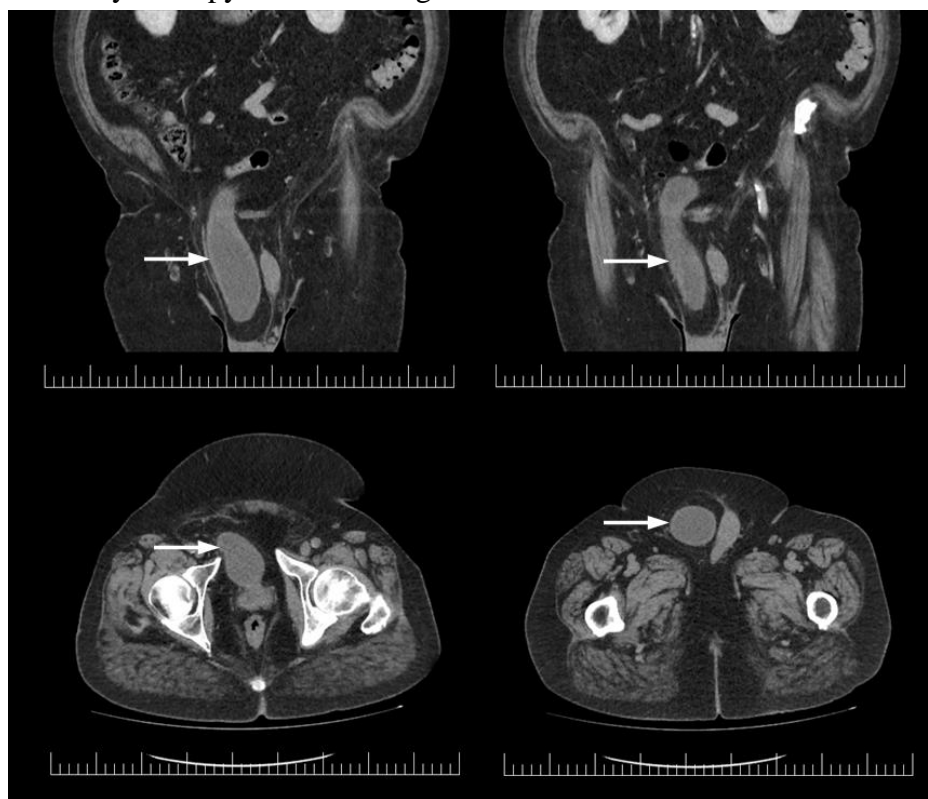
CT scan. The urinary bladder (white arrow) is herniated in the right scrotum. There was no obstruction of the ureters. No bladder mass was present.
